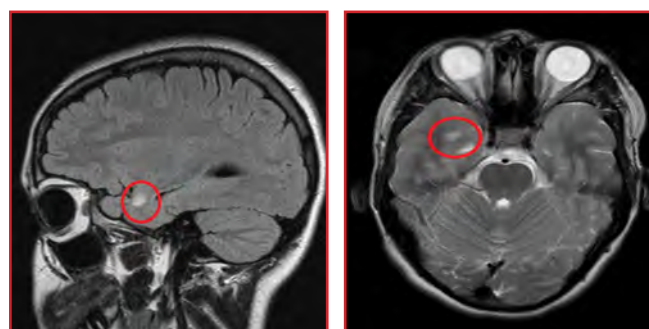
T2-weighted magnetic resonance imaging results of the brain using contrast agents, showing abnormal findings of an enhancement (circled) in the frontal subcortical white matter.
